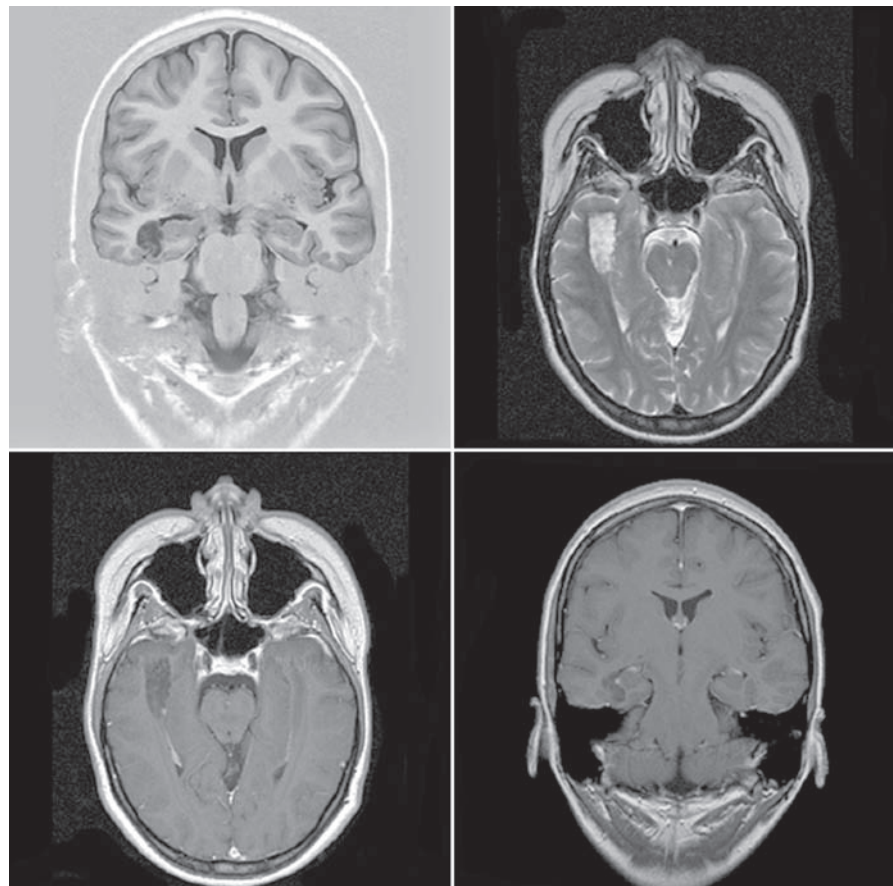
Dysembryoplastic neuroepithelial tumor of the right temporal lobe. The tumor is hypointense on inversion recovery (*upper left*), as well as on T1-weighted images (*lower left and right*). There is no contrast enhancement (*lower left and right*). On T2-weighted images, the tumor is hyperintense (*upper right*). The tumor appears to be multinodular on all sequences. There is no notable mass effect or peritumoral edema
